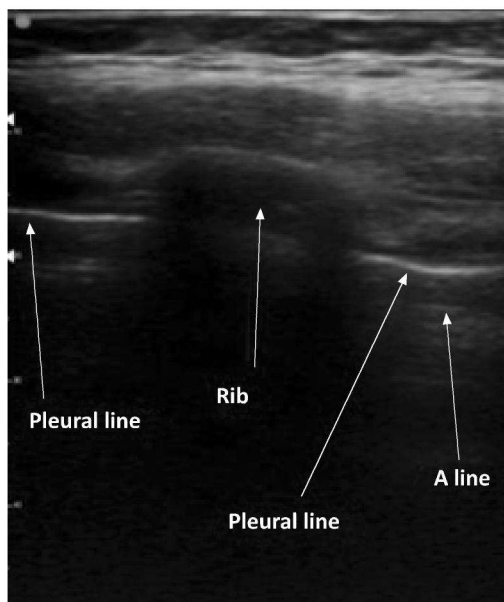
A rib bordered by the pleural line on both sides. The rib shadow does not allow the pleura to be seen behind it. The pleura appears as a thin shiny white line, and it slides with respiration. A-lines are artefacts which are seen due to ultrasound reflections from the pleura.
